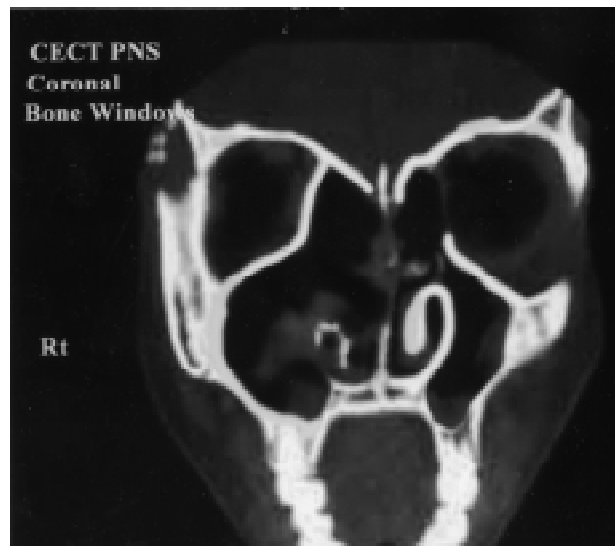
Contrast enhanced CT of the paranasal sinuses (coronal section - bone windows) showing destruction of the medial wall of the maxillary sinus, middle turbinate and the uncinate process of the right side
